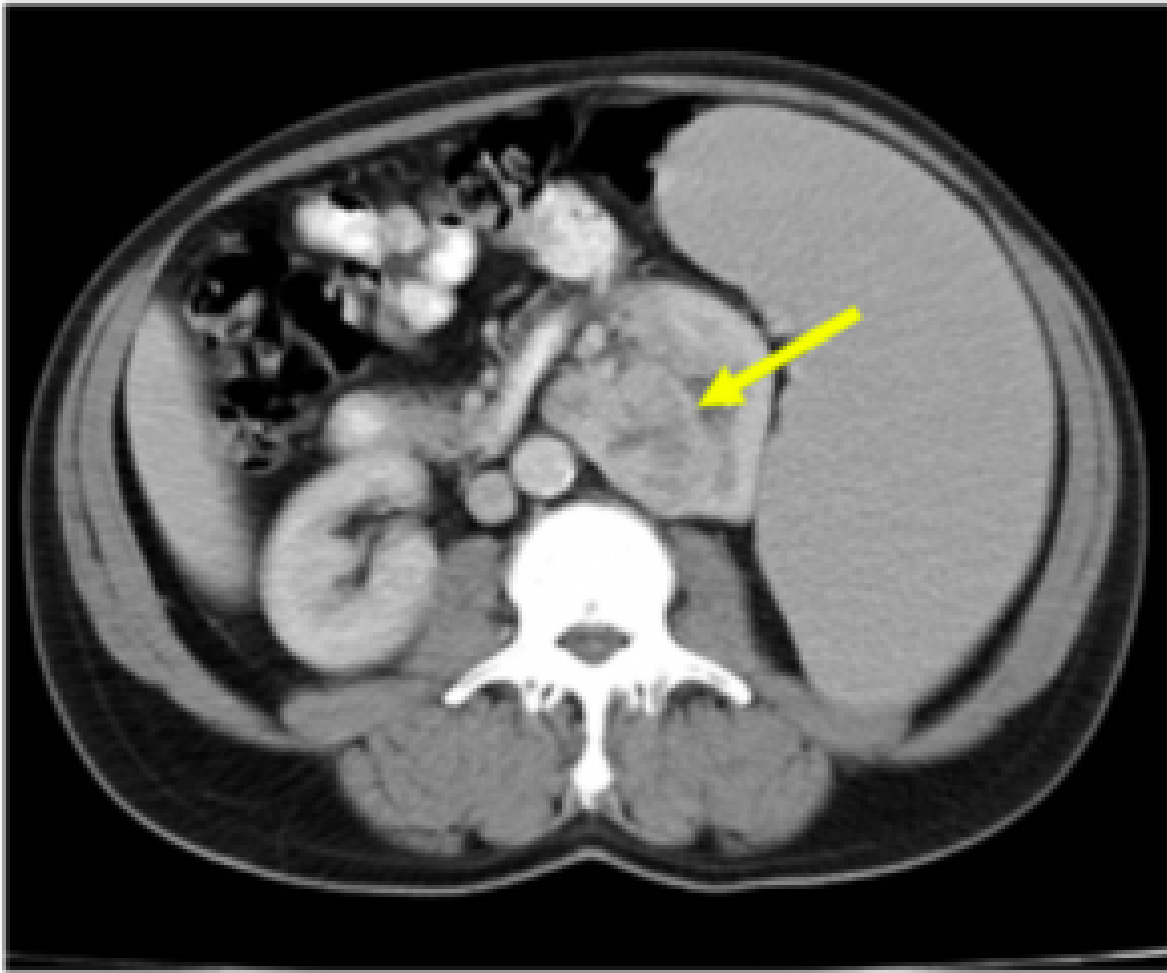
Computed Tomography shows splenomegaly and left renal carcinoma (yellow arrow).¹
